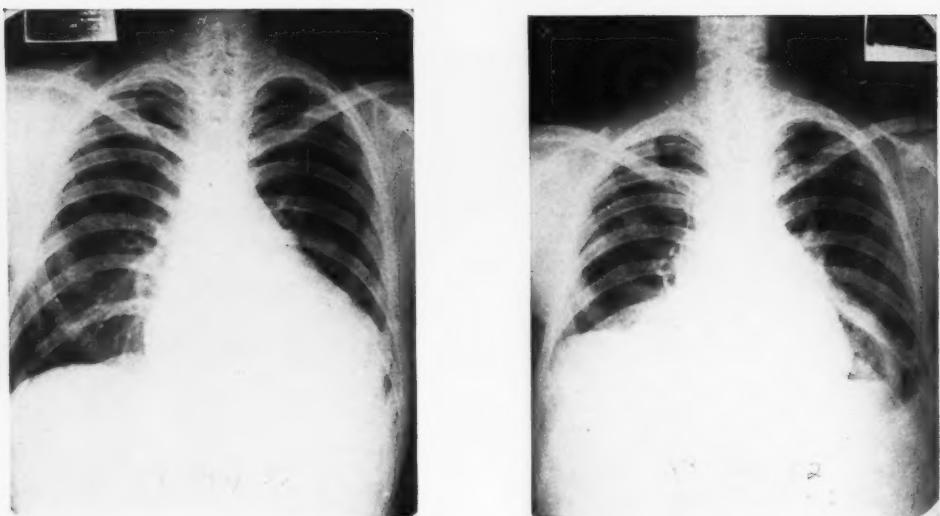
(left). X-ray film of chest of patient shown in figure 4 with a large pericardial effusion.
